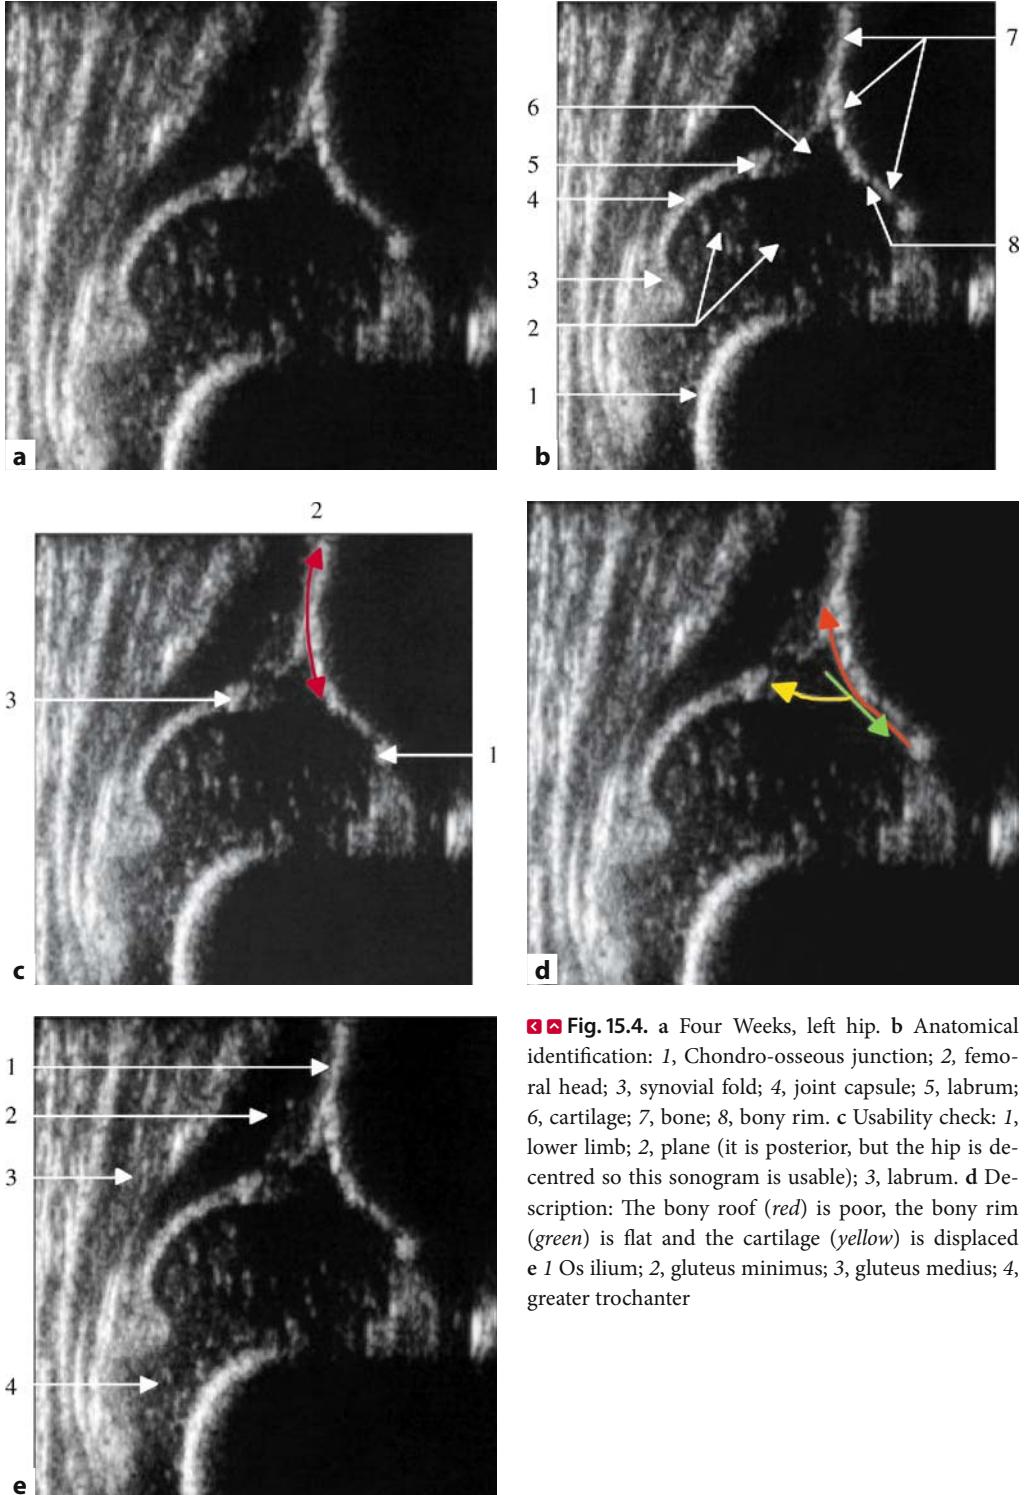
a Four Weeks, left hip. b Anatomical identification: 1, Chondro-osseous junction; 2, femoral head; 3, synovial fold; 4, joint capsule; 5, labrum; 6, cartilage; 7, bone; 8, bony rim. c Usability check: 1, lower limb; 2, plane (it is posterior, but the hip is decentred so this sonogram is usable); 3, labrum. d Description: The bony roof (*red*) is poor, the bony rim (*green*) is flat and the cartilage (*yellow*) is displaced
